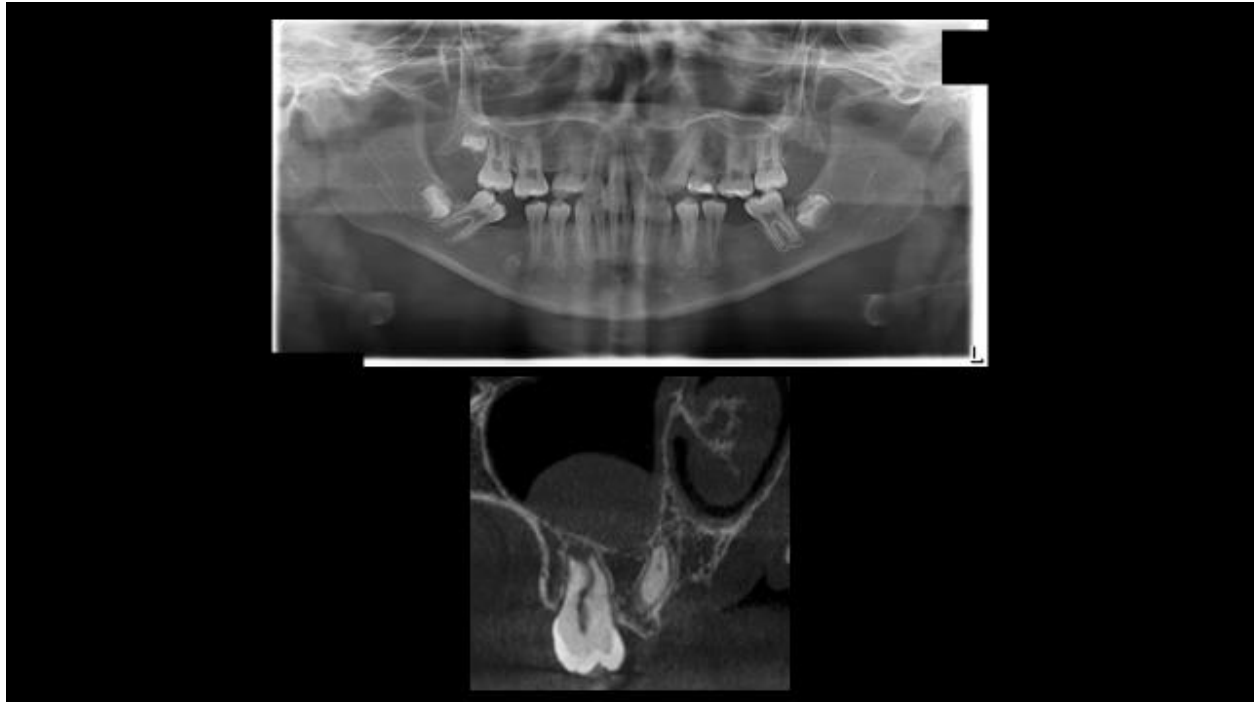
Mucus retention pseudocyst CBCT (bottom) not visible on PAN (right)
